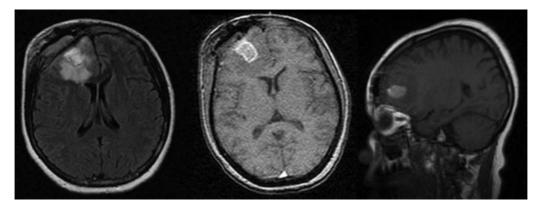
An MRI shows the frontal and interhemispheric pachymeningeal thickening, which is predominantly right, associated with contrast enhancement. The presence of impairment of the cranial calotte and infiltration of the superior frontal gyrus and frontobasal can be observed.
